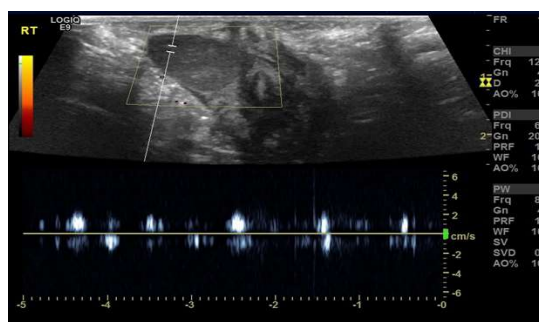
Spectral Doppler waveform image appears to reveal a faint arterial waveform within the lesion.
